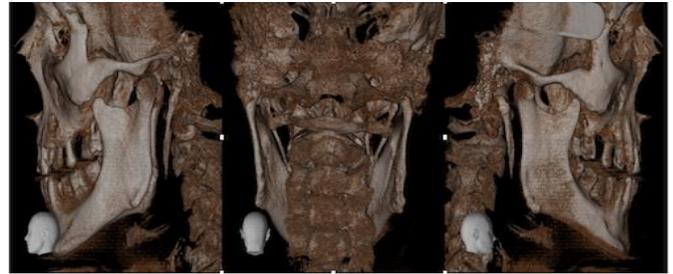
CBCT showing left and right elongated styloid processes in case #1.
